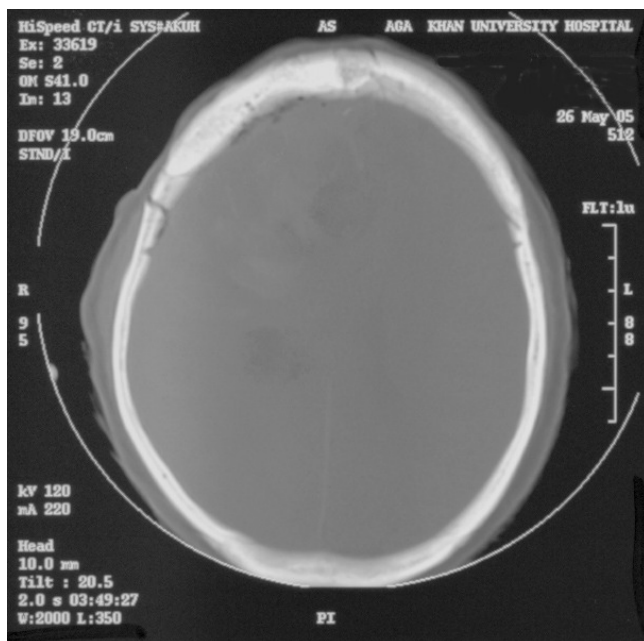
Post-cranioplasty CT scan, bone window showing no evidence of residual tumor.
